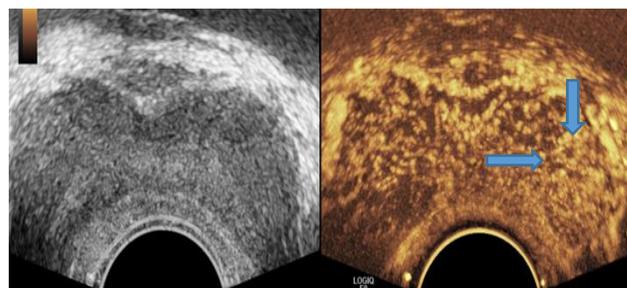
Grayscale and SHI at the base of the prostate obtained in a patient with prior negative MRI. Arrows point to an area of increased contrast enhancement at the left base. The targeted biopsy from this area demonstrated a Gleason 6 PCa.
